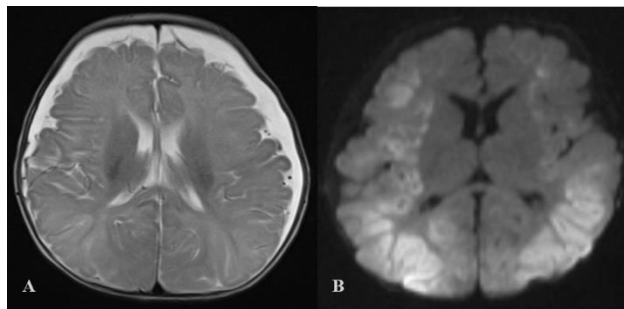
A 3-month-old female patient presenting with recurrent seizures and fever. A) T2W axial MR image showing subdural effusion along bilateral fronto-parieto-temporal convexities. B) DWI axial MR image showing areas of acute infarct (hyperintense) in bilateral cerebral hemispheres.
